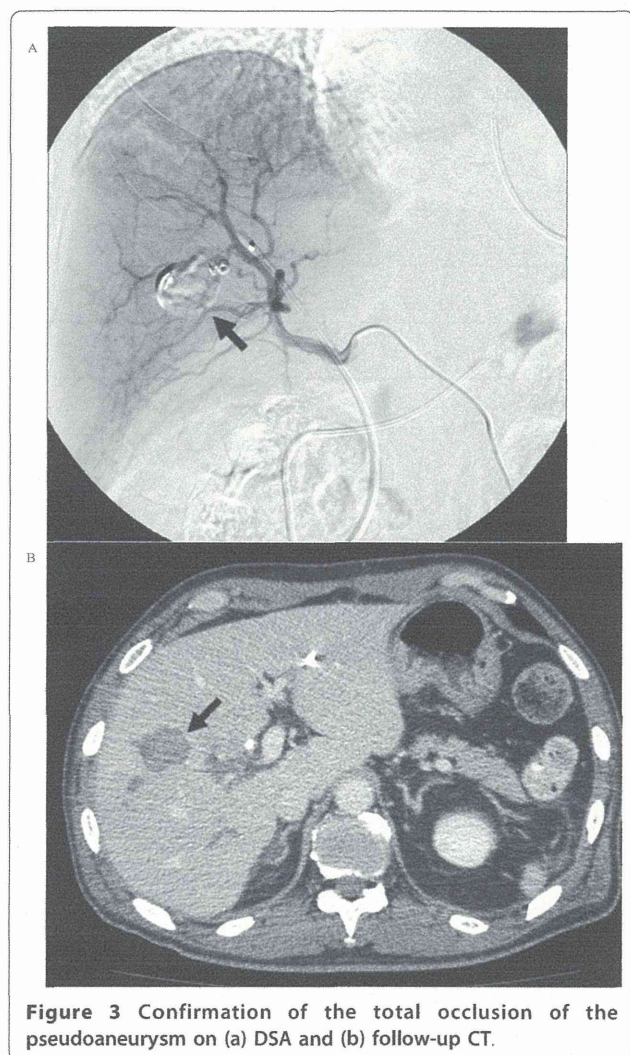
Confirmation of the total occlusion of the pseudoaneurysm on (a) DSA and (b) follow-up CT.
